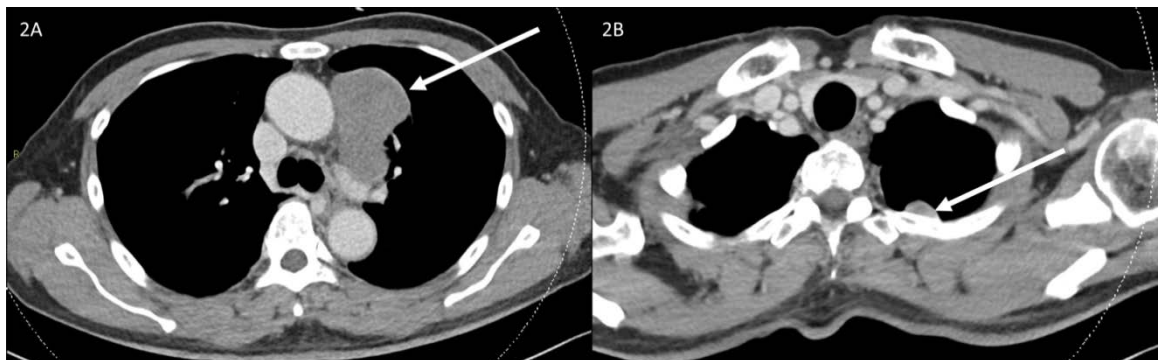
Axial contrast enhanced CT demonstrating (white arrows) a lobulated soft tissue mass inseparable from the left mediastinal pleura anteriorly mimicking an anterior mediastinal mass (2A) and a left lung apex pleural based nodule (2B). *TECHNIQUE:* CT – 90.0 KV; Slice thickness – 3mm; Late arterial phase.
